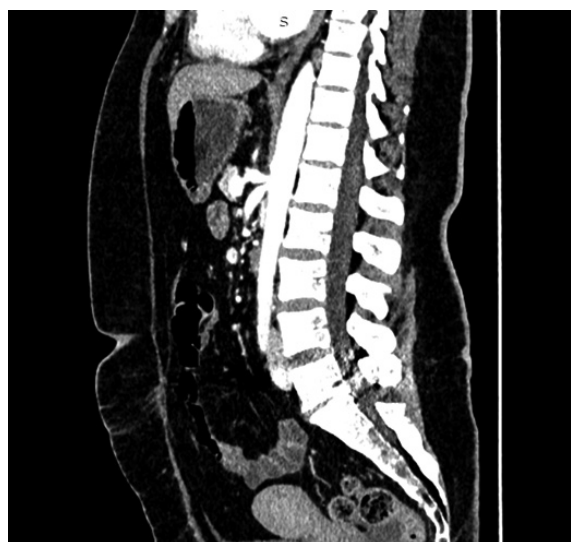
CT of the abdomen, sagittal view
